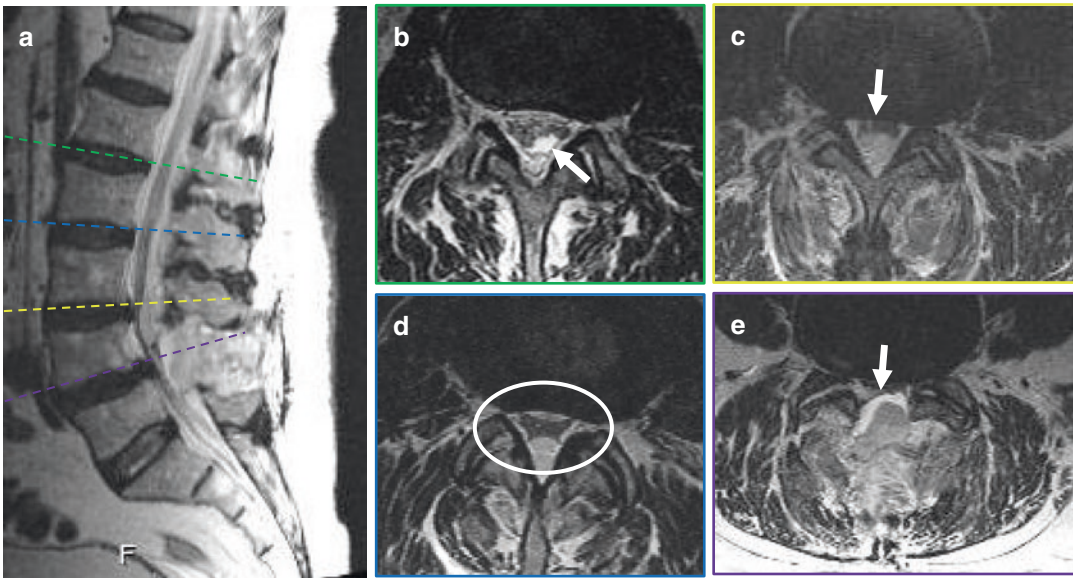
A 76-year-old man presenting with right lower extremity weakness following midline laminectomy at L4–5. Sagittal T2-weighted MR image (a) demonstrates a heterogeneous mass-like collection at the laminectomy site compressing the cauda equina. Axial T2-weighted image at L1–2 (b) demonstrates a fluid collection of questionable location (arrow), possibly subdural, causing centralization of nerve roots. Axial image at
